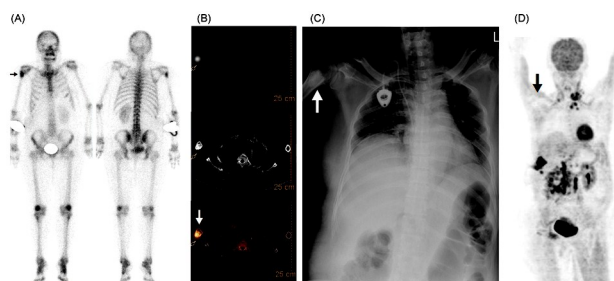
(A) The planar bone scan: focal intense uptake in proximal portion of right humeral shaft. (B) The SPECT/CT study: irregular areas with various ossification and cystic formation in right proximal humeral cortex and adjacent marrow space on the reference CT images. (C) This finding was not pointed out on the first interpretation of a previous chest plain film. (D) Maximum intensity projection ^{18}F -FDG PET/CT images: no obvious ^{18}F -FDG uptake in this area.
